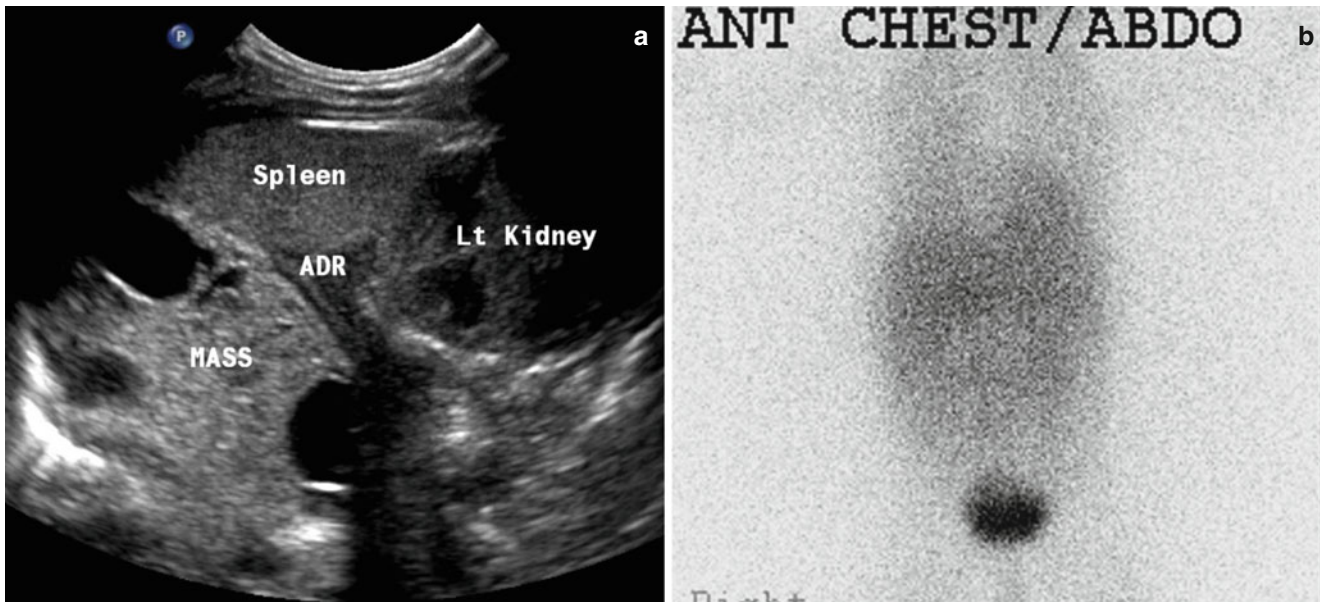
Neuroblastoma in the left suprarenal region. (a) Ultrasound shows the relationship of the left kidney, spleen and the normal left adrenal to the left sided suprarenal mass. (b) MIBG performed at the same time shows no uptake by the tumor
